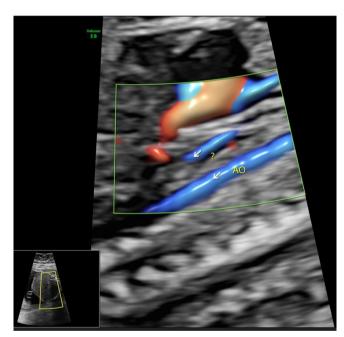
Fetal ultrasound image showing an abnormal vessel. Ultrasound image from examination at 21.3 weeks of gestation
